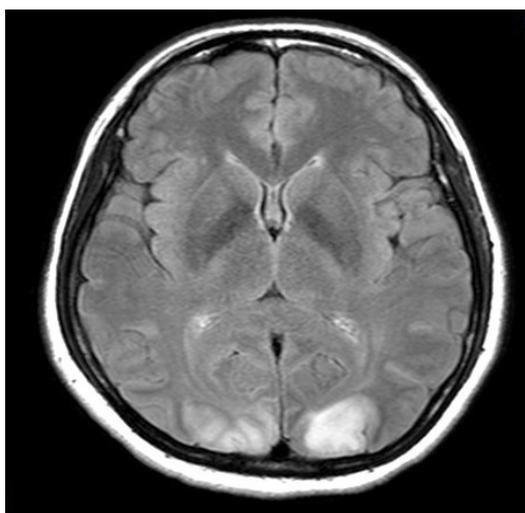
Magnetic resonance imaging (MRI) FLAIR showing hyperintensity over the occipital lobes bilaterally, suggesting infarct.
